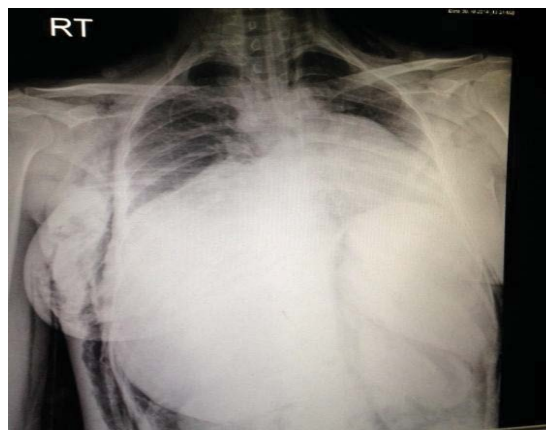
Chest X-ray posteroanterior view: Upwards displacement of the lungs and heart by abdominal mass, chest and abdominal surgical emphysema on the right side and abdominal emphysema on the left side.
